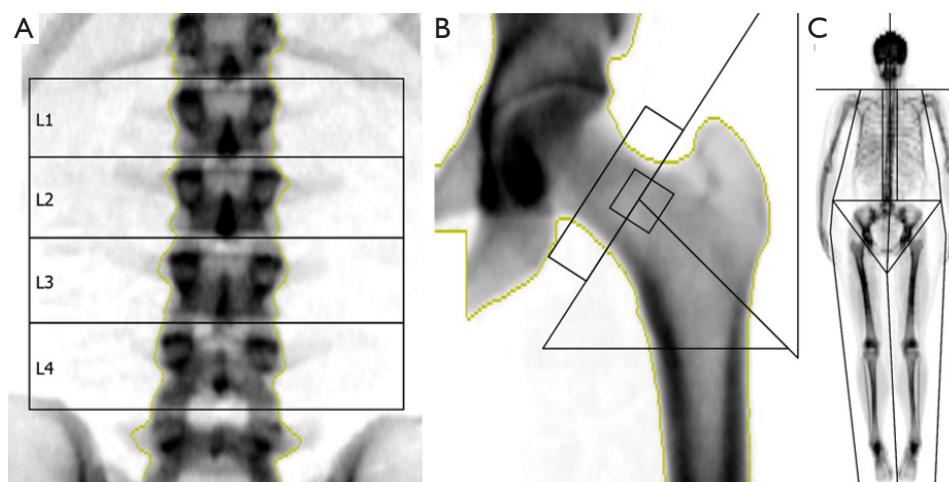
Example DXA images of the lumbar spine (A), femoral neck (B) and total body (C) with corresponding regions of interest in which BMD is measured. DXA, dual-energy X-ray absorptiometry; BMD, bone mineral density.
